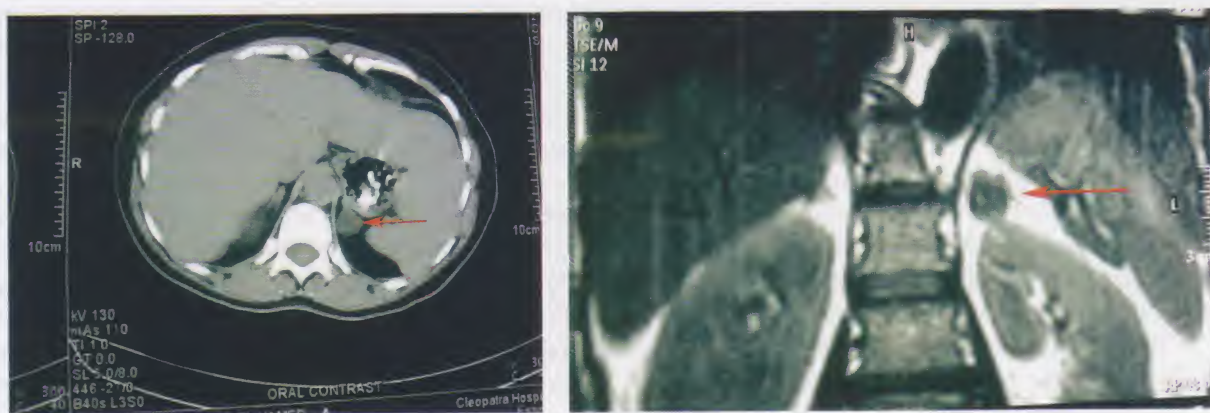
CT (left) and MRI (right) of the abdomen of the same patient showing a left adrenal adenoma
